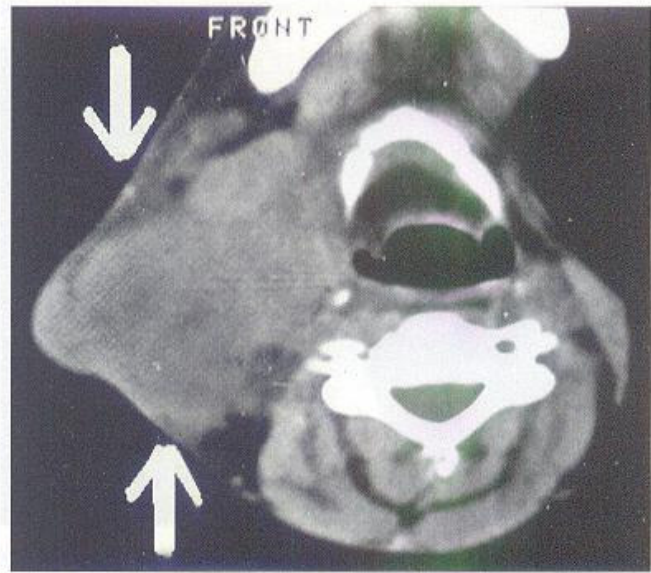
CT scan showing parotid tumour right sided. Depth, deep lobe involvement and nodal status should be assessed.
